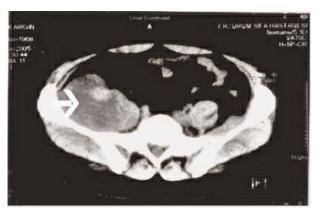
The computed tomographic scan showed a large mass (white arrow) sized as $30 \times 13 \times 8$ cm under the right posterior pararenal space and adjacent of the iliopsoas muscle.
